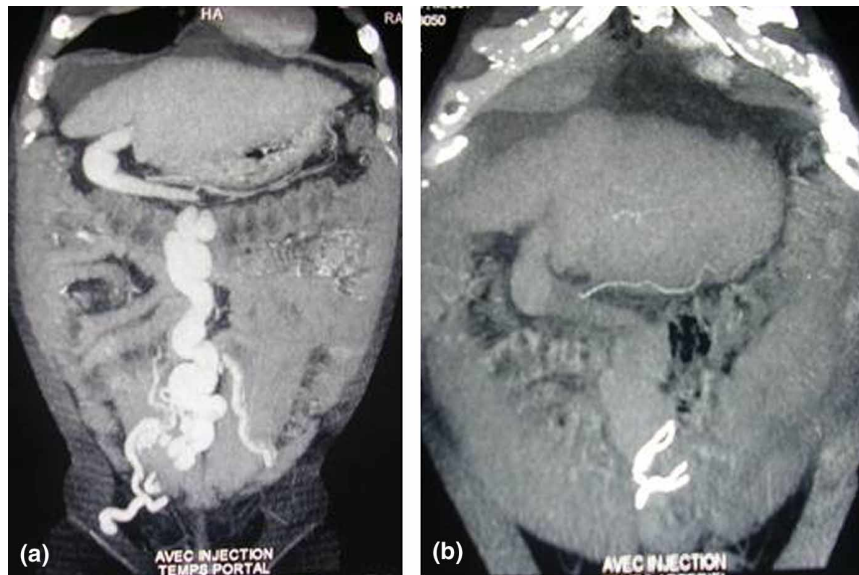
(a) Preoperative CT scan showing the shunt forming by re-permeabilization of the umbilical vein to the iliac vein. (b) Postoperative CT scan showing disconnection of the shunt and disappearance of the latter.
